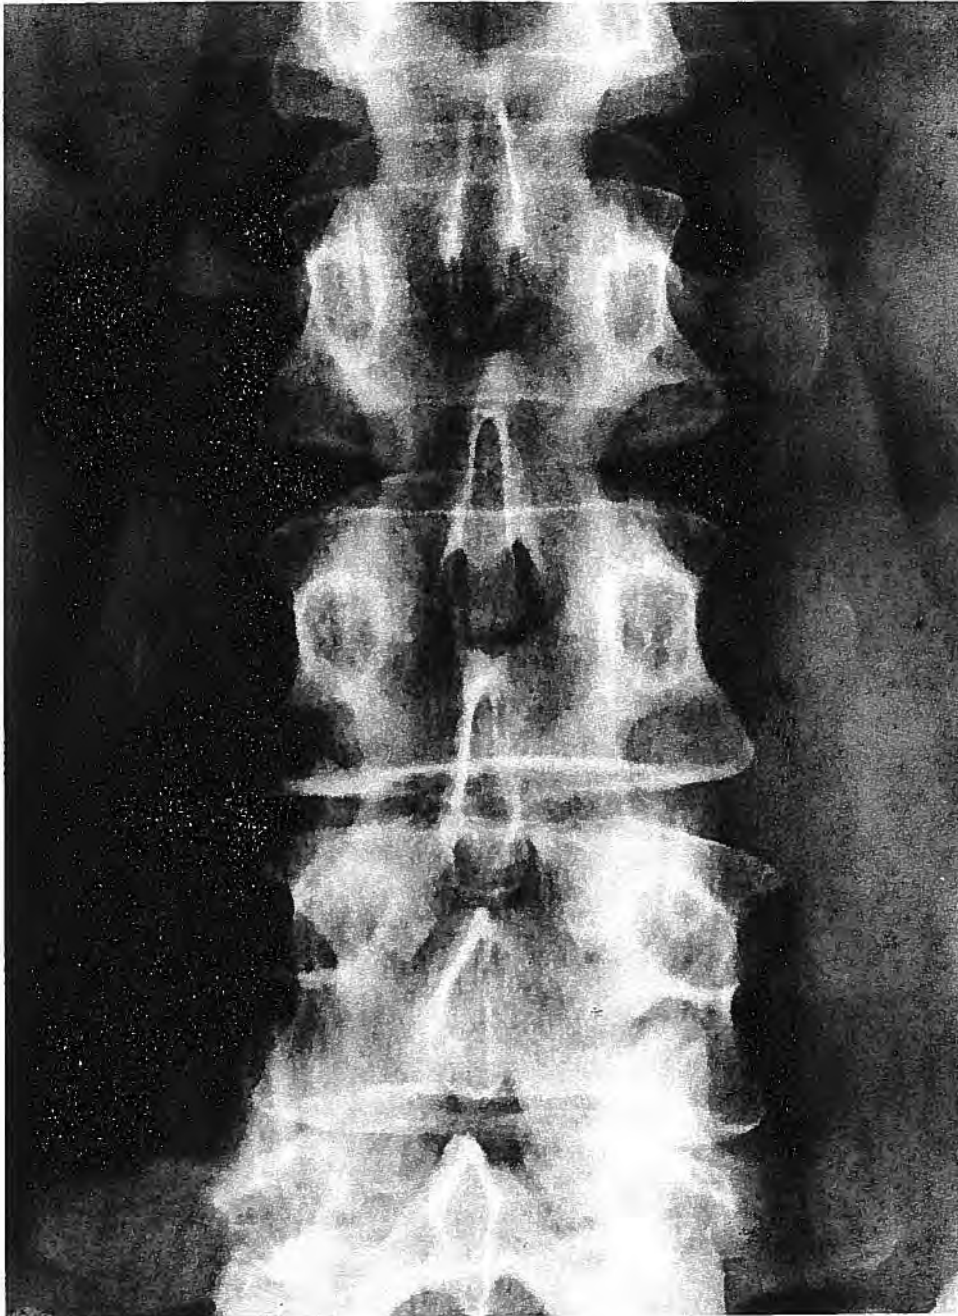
An antero-posterior radiograph of the lumbar spine in an adult in whom gross pathology is noted, particularly in the roof of the spinal canal. Although there is evidence of spondylosis at L3/4 with asymmetrical narrowing of the disc space, the major changes are in the laminal structures where facet hypertrophy, laminal thickening and spinous process interdigitation have reduced the interlaminar spaces at L2/3 and L3/4 to minute porportions
